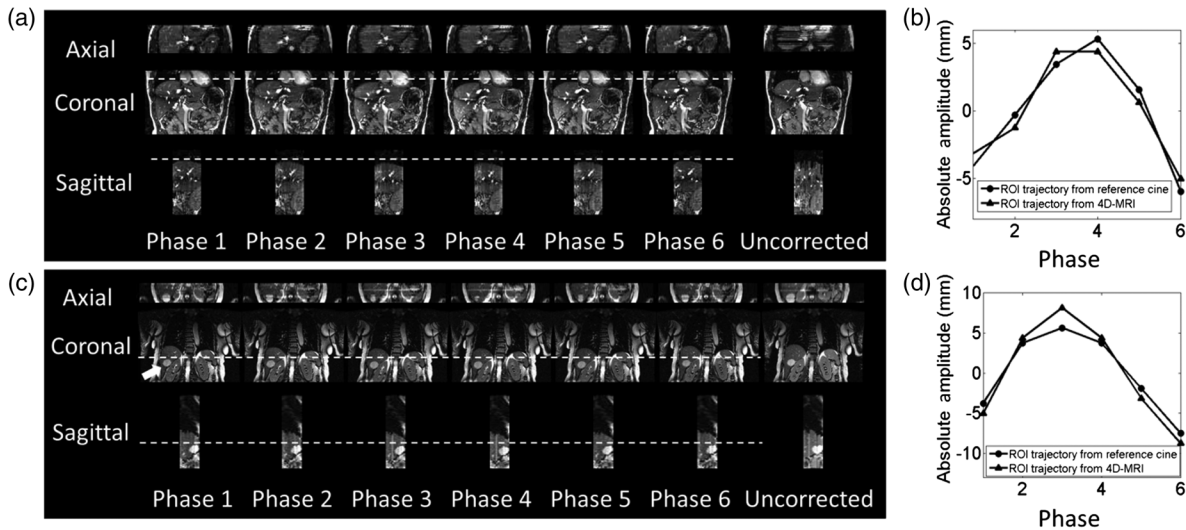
(a) Six-phase 4-D-MRI images, with uncorrected images as comparison and (b) comparison of ROI motion trajectories between 4-D-MRI and reference cine MR for a representative healthy volunteer. (c) Six-phase 4-D-MRI images (white arrow points out a cyst in liver), with uncorrected images as comparison and (d) comparison of ROI motion trajectories between 4-D-MRI and reference cine MR for a representative cancer patient. A benign cyst in the liver is pointed out by the white arrow.
